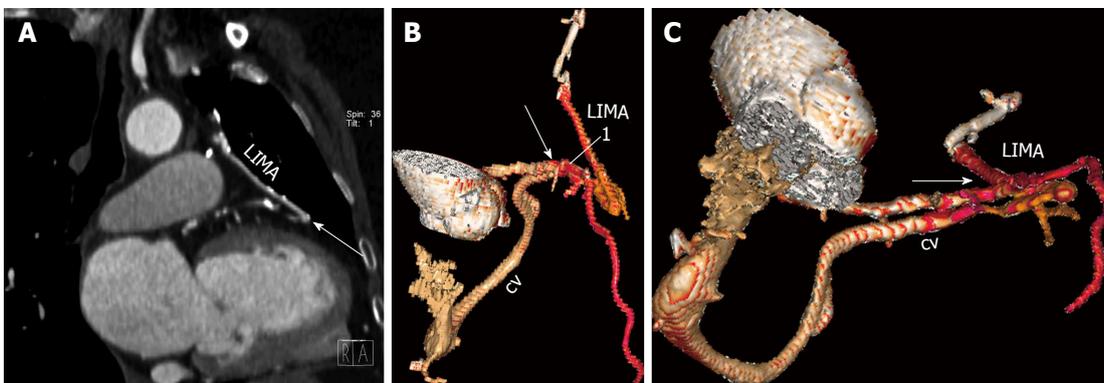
Coronary artery bypass graft to cardiac vein fistula. A: Coronal coronary computed tomography angiography image shows a fistulous communication (arrow) between the left internal mammary artery (LIMA) graft and the great cardiac vein (CV); B: 3D volume rendered computed tomography (CT) image shows fistulous communication (arrow) between the LIMA graft and the great CV; C: Axial oblique reconstructed 3D volume rendered CT image demonstrates the fistulous communication (arrow).
